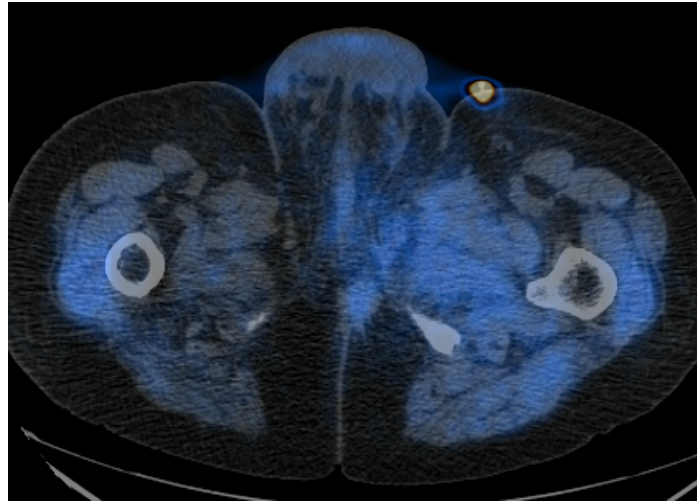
^{18}F Choline axial fused PET/CT images in a patient post radical prostatectomy . There is a spiculated mildly avid soft tissue abnormality in the left ischio-rectal fossa, which was a metastatic deposit from prostate cancer. Focal intense uptake at the left inguinal region is excreted activity in the drainage tube of urinary catheter.
